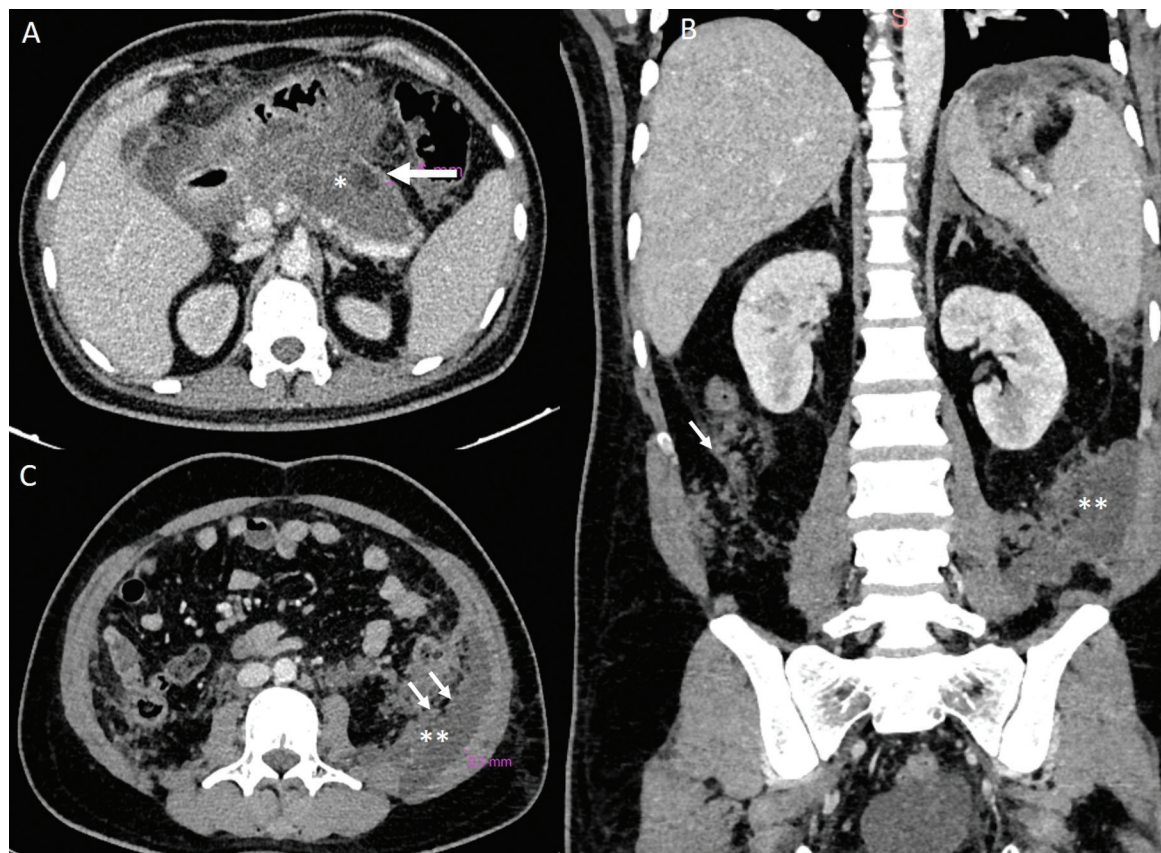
Baseline contrast-enhanced computed tomography (A, B: axial sections; C: coronal reformatted images) in a 62-year-old male with alcohol-induced pancreatitis on day 12 of illness shows partially encapsulated lesser sac (*) collection (~40–50%) and partially encapsulated left pararenal collection () with unencapsulated anterior aspect (white arrows).
